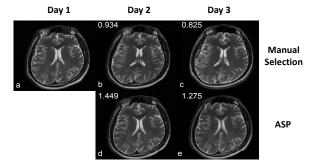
T2-weighted images acquired in different days. (a,b,c) manually selection according to TOF(d,e) slice selection by ASP. In (b,c,d,e), each mutual information with (a) is noted on the left-top. Notice that MI values of (d,e) are higher than (b,c)
